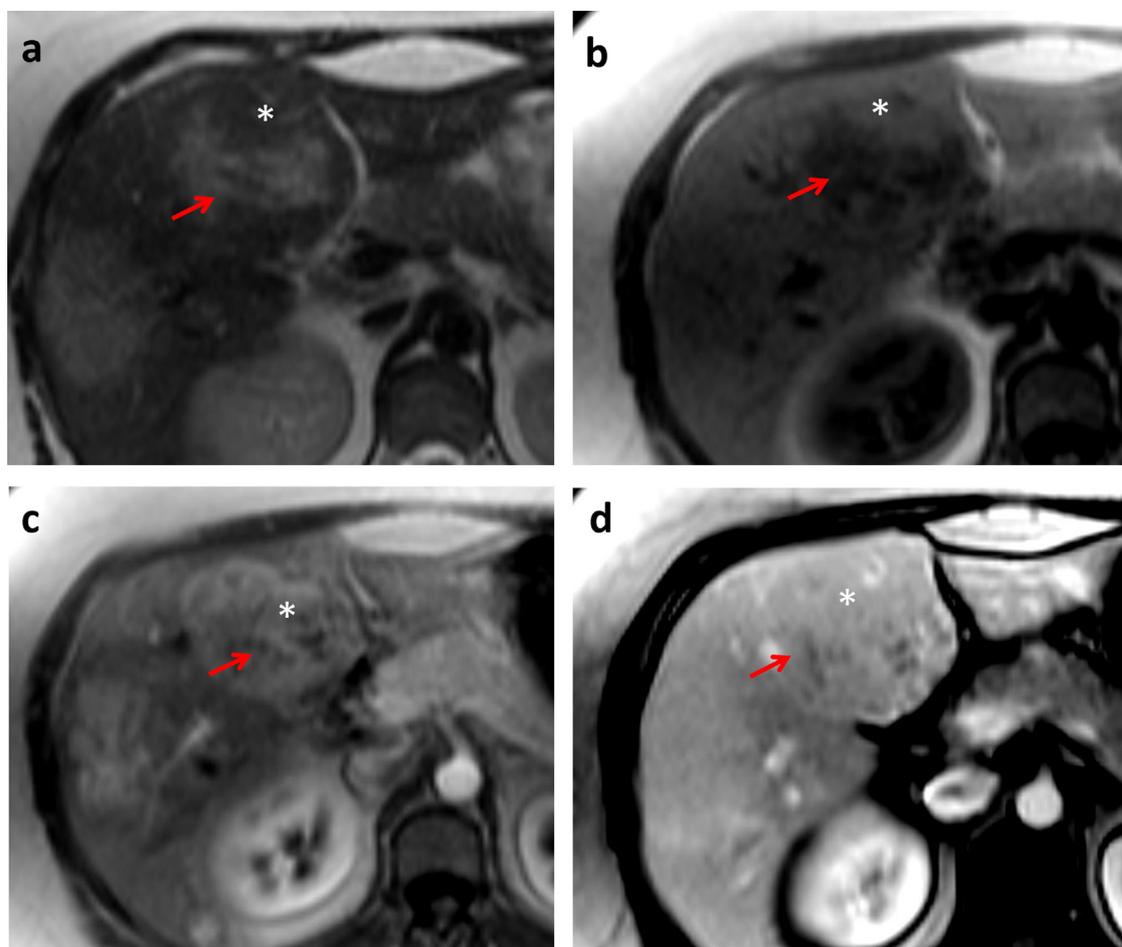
MRI nodule N1 (ASS1 + HCA); a: T2 weighted imaging : the lesion (*) is isointense to surrounding liver with focal central "confluent" cavities with strong hypersignal (red arrow); b: T1 weighted imaging : the lesion (*) is isointense to surrounding liver with focal central cavities in hyposignal (red arrow); c: Arterial phase: strong arterial heterogenous enhancement of the lesion (*) with no enhancement of the central 'fluid cavities' (red arrow); d: Portal venous phase : the lesion (*) remained heterogenous in isosignal to surrounding liver with central fluid cavities in hyposignal (red arrow).
